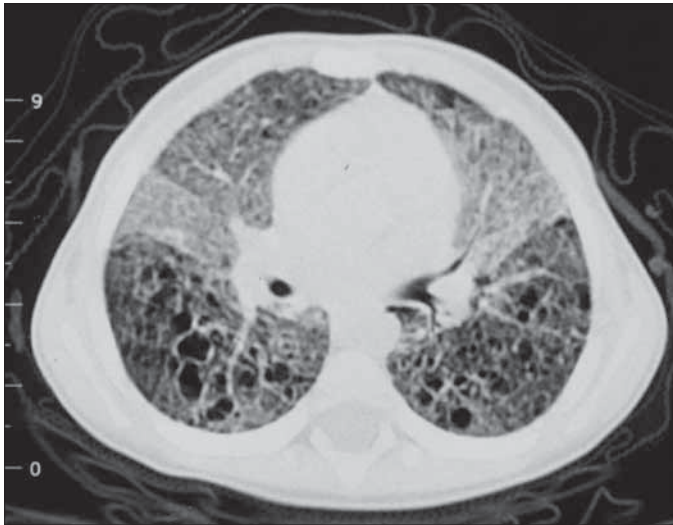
HRCT demonstrating peribronchial nodules and cystic changes
